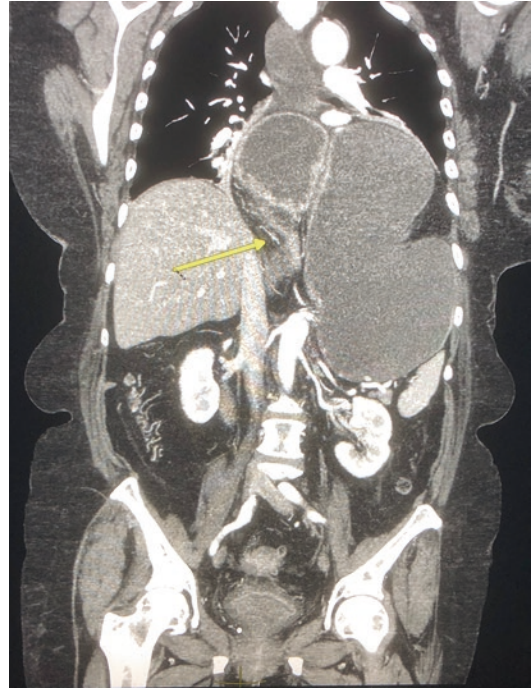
CT scan of large paraesophageal hernia causing gastric outlet obstruction with arrow indicating area of obstruction
